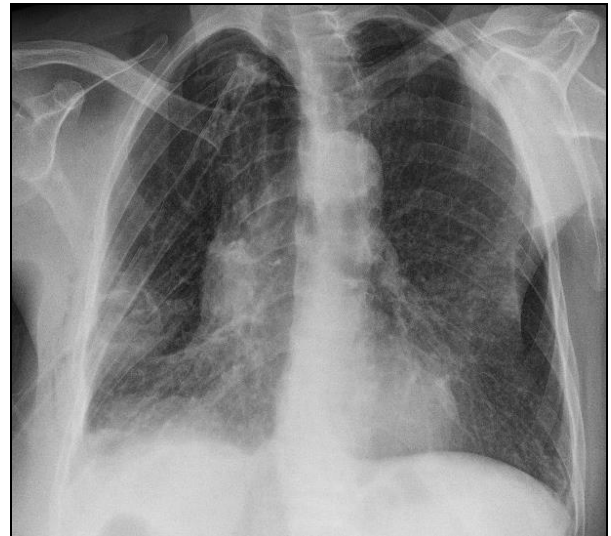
Chest X-ray of the patient after tube thoracostomy.
